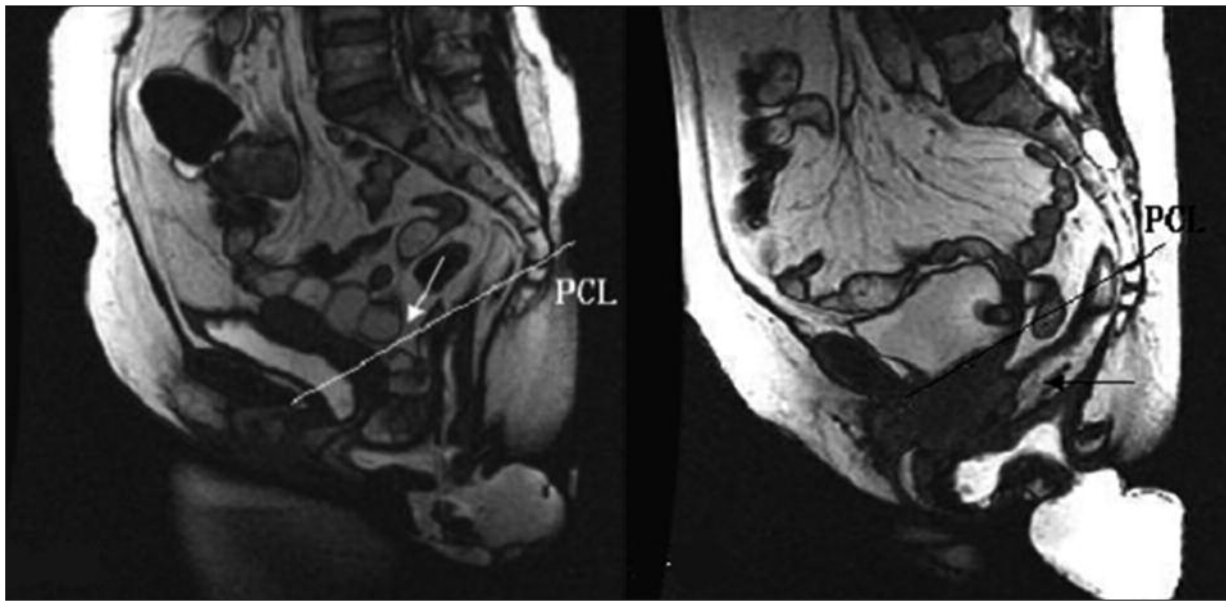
Chronic constipation and straining during defecation in a 32-year-old woman. Sagittal True-FISP MR image of the patient during straining shows lack of pelvic floor descent during defecation and a paradoxical contraction of the puborectal muscle with a failure of the anorectal angle to open, resulting in prolonged or incomplete evacuation. A, The anorectal angle was 90°, and B the axial T2-weighted turbo spin-echo MR image reveals a hypertrophic puborectal region.
